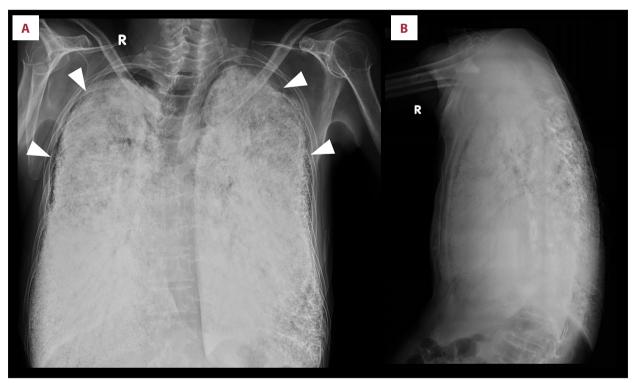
(A, B) Chest X-ray. Chest X-ray with posteroanterior and lateral view shows a pattern of diffuse opacity of high density with symmetrical and bilateral micronodular patterns. Notice the subpleural lucency in keeping with the black pleural line (arrow head).
